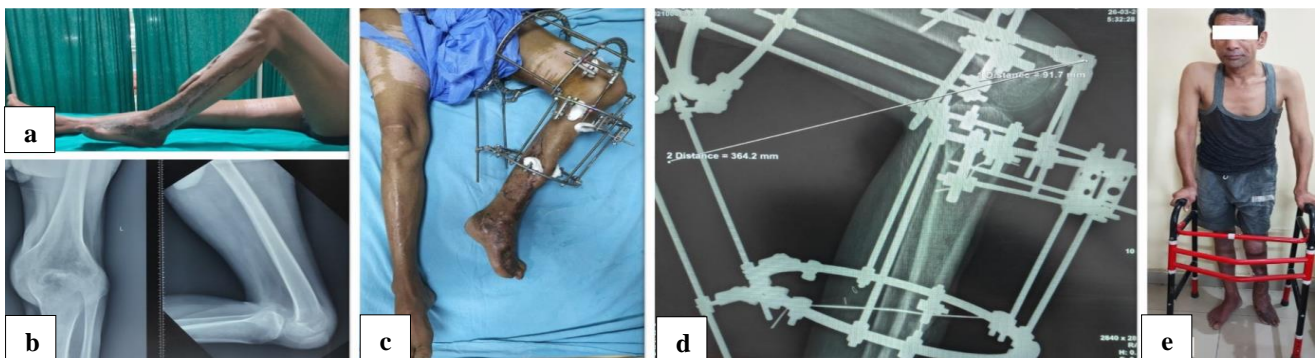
Representative images of case 2: (a) clinical image showing left hip and knee flexed, along with multiple healed scar marks with a thick flap over the leg, great toe, second and third toe were amputated with the healthy stump; (b) plain radiographs of the left knee showed a fixed flexed knee with posterior subluxation of the knee; (c) post-operative image of lower limbs after knee spanning hinged-based Ilizarov fixator application; (d) post-operative radiographs showing Ilizarov fixator in place where distraction started according to the law of a similar triangle; and (e) clinical image at final follow-up, where patient was able to stand on his own with support from an extended knee.
